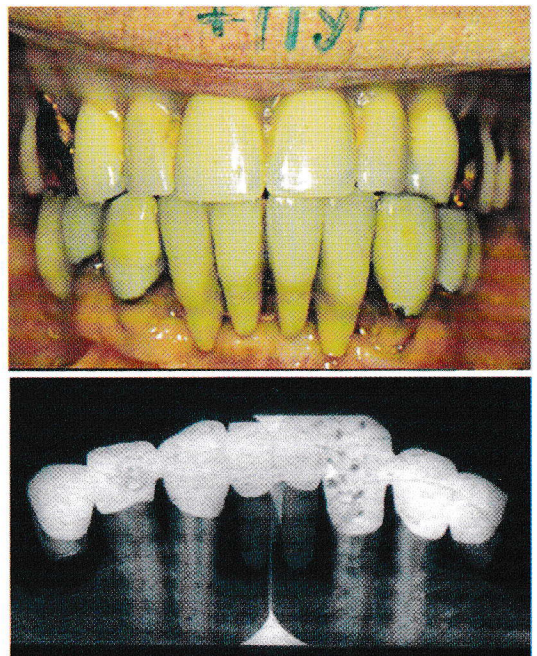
Clinical view and radiographs taken 11 years after insertion of the mandibular 10-unit FDP in a 70-year-old man, who still had the FDP when he died at age 84.
